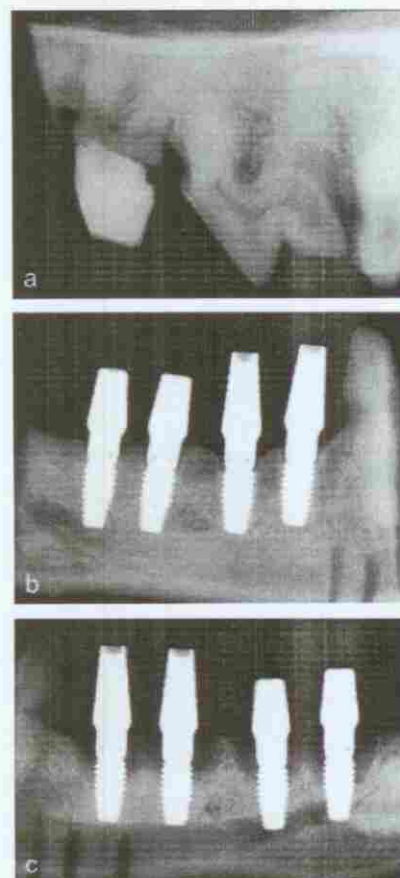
Radiographs taken at the end of the experiment. (a) Opposite tooth (P4) presenting radiographic evidence of marginal and inter-radicular alveolar bone loss and intrusion. (b) Uninfamed site: slight crestal bone resorption apically to the top of the implant neck but not beyond the bottom of the neck. (c) Inflamed site: pronounced circumferential bone resorption with significant implant thread exposure in both overloaded and unloaded implants.
